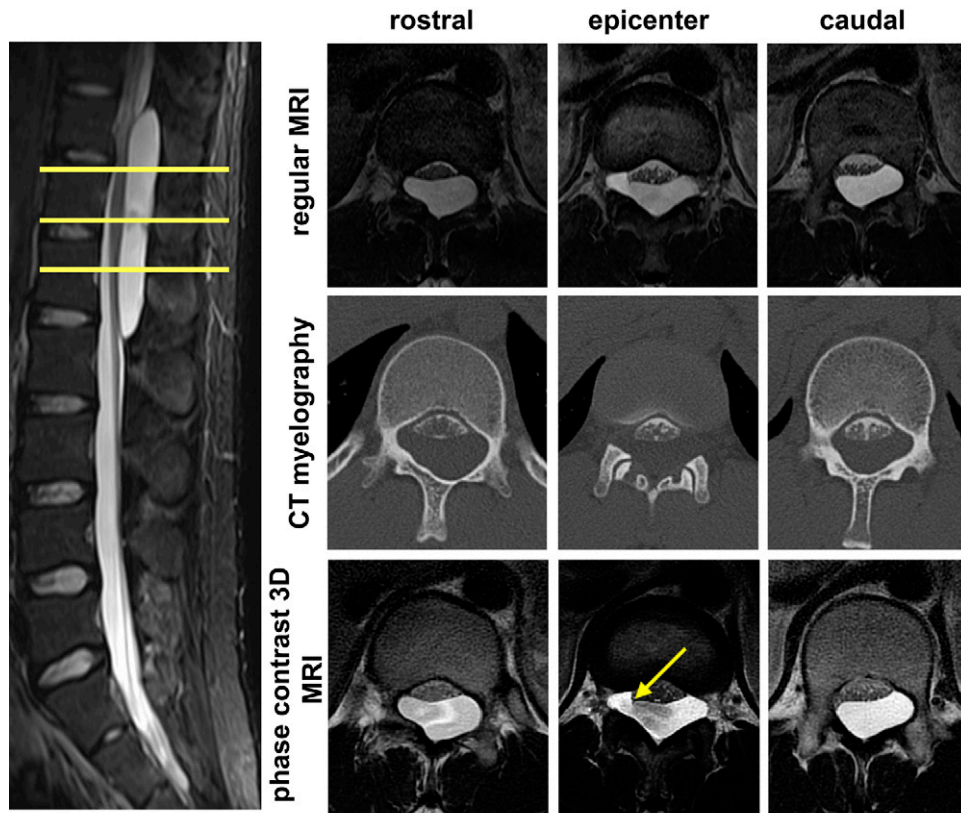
Left: Preoperative sagittal T2-weighted MRI scan showing a large spinal extradural arachnoid cyst from T10 to L1 (*yellow lines*). Upper right: Axial regular MRI. Center right: Axial CT myelography. Lower right: 3D phase-contrast MRI scans obtained at each sagittal cutline. Regular MRI and CT myelography show no obvious communication between the cyst and the intrathecal subarachnoid space. The rostral view of the CSF wave and phase-contrast MRI scan show a clearer view of the CSF flow, suggesting that the communicating hole (*yellow arrow*) is at the T12 level.
